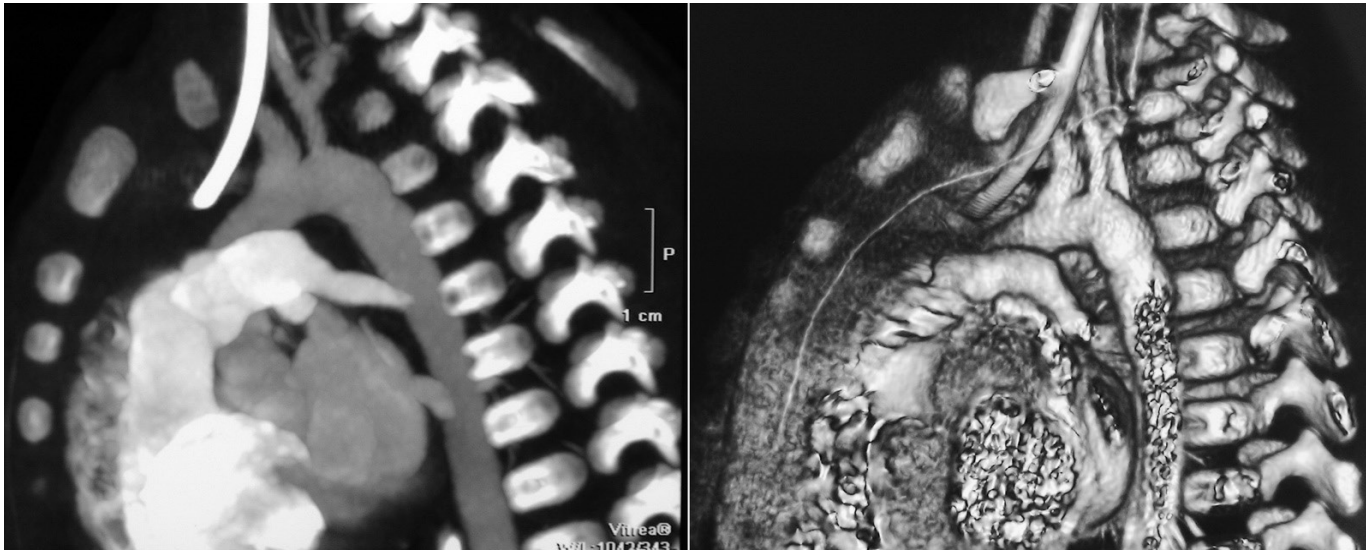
Absence of arch deformation and left subclavian artery patency were confirmed with multislice spiral computed tomography.
